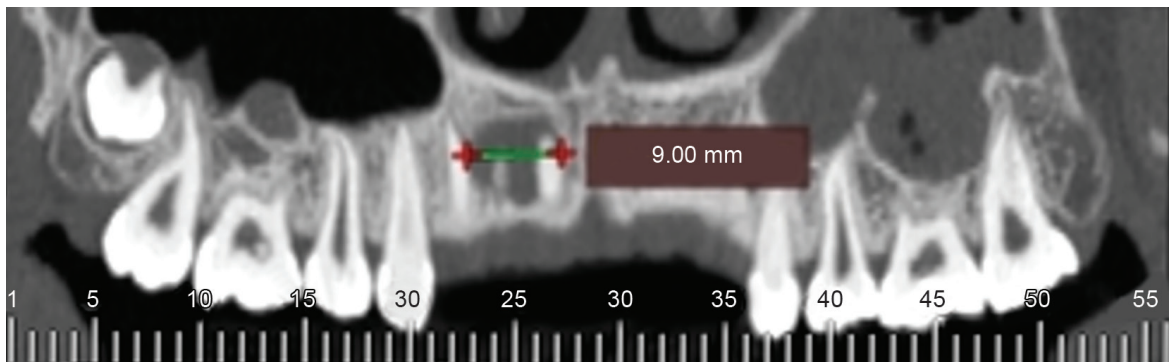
CBCT scan image showing maximum diameter in the mesiodistal direction
